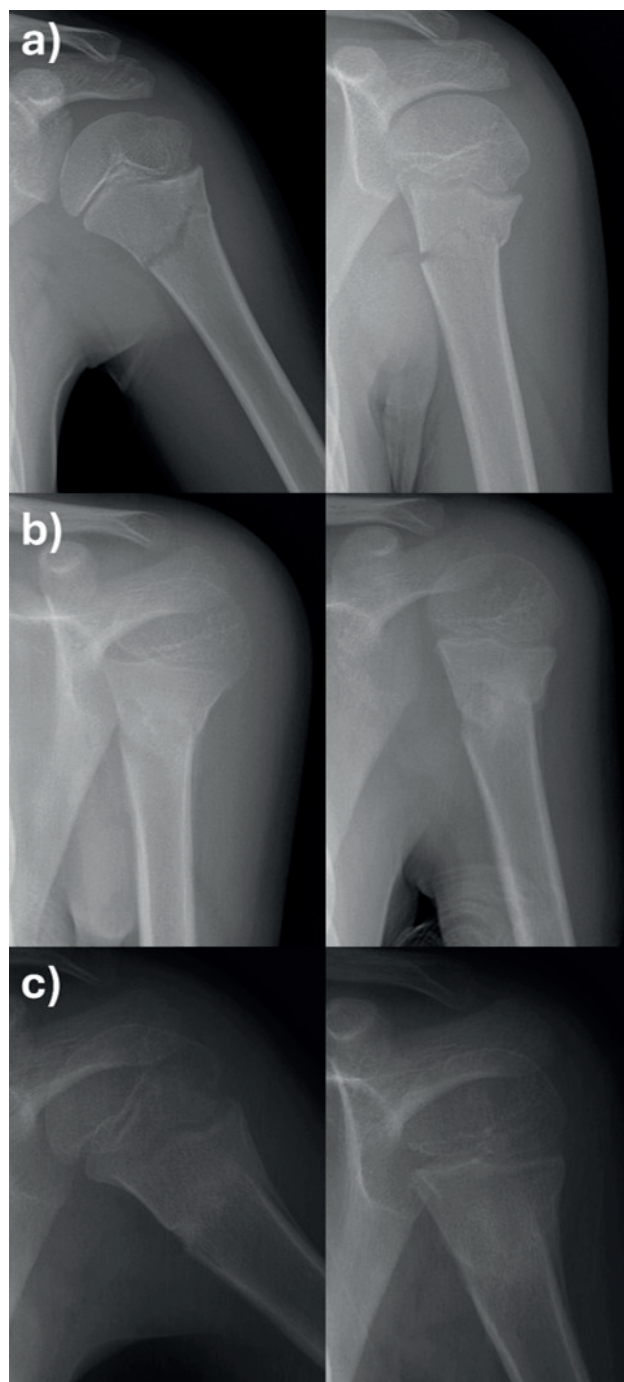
Radiographs of a 7-year-old. Left proximal humerus fracture after falling while playing
